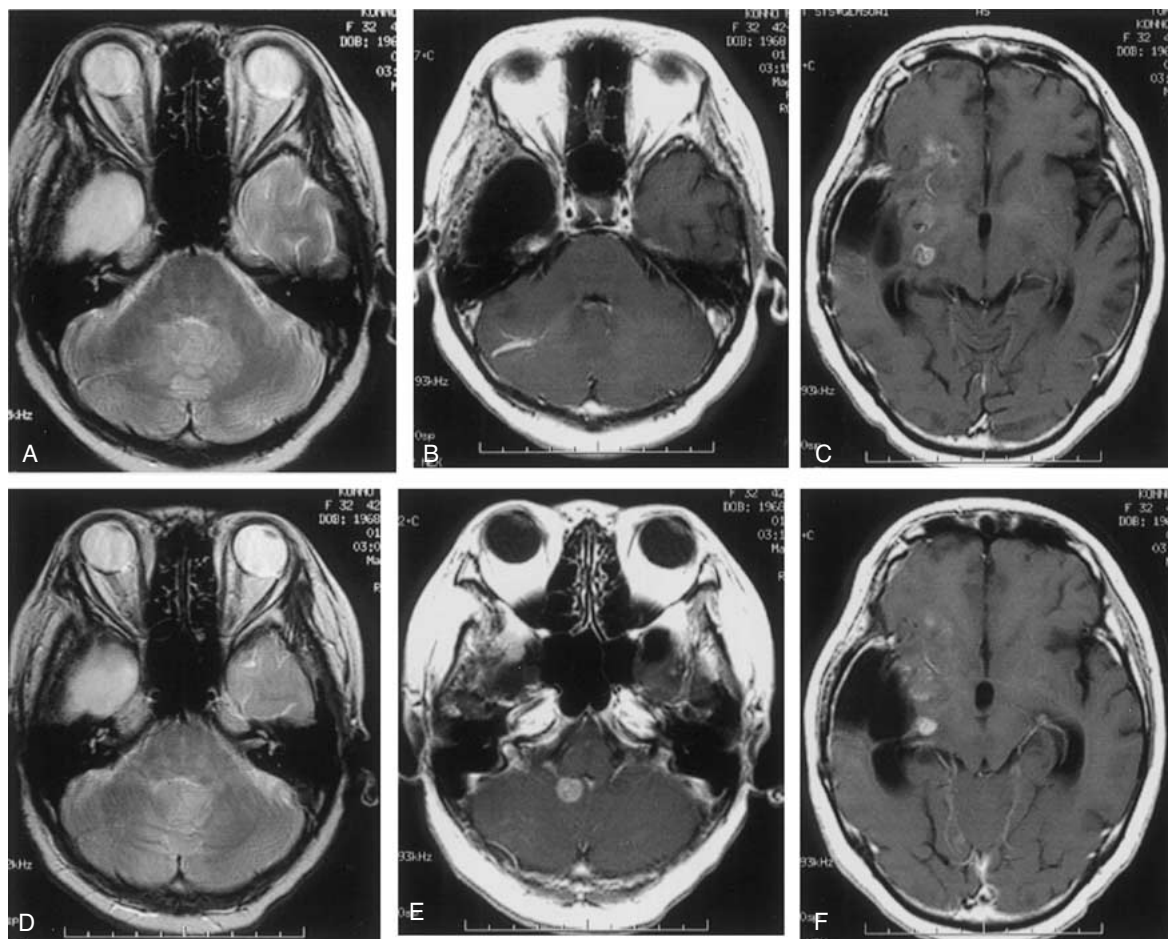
Case 4. T2-weighted (A, D) and T1-weighted MR images with Gd-DTPA (B, C, E, F). The CSF seeding was not evident around the fourth ventricle 1 month after presentation with intractable vomiting (A–C), but appeared 2 months later (D–F).
